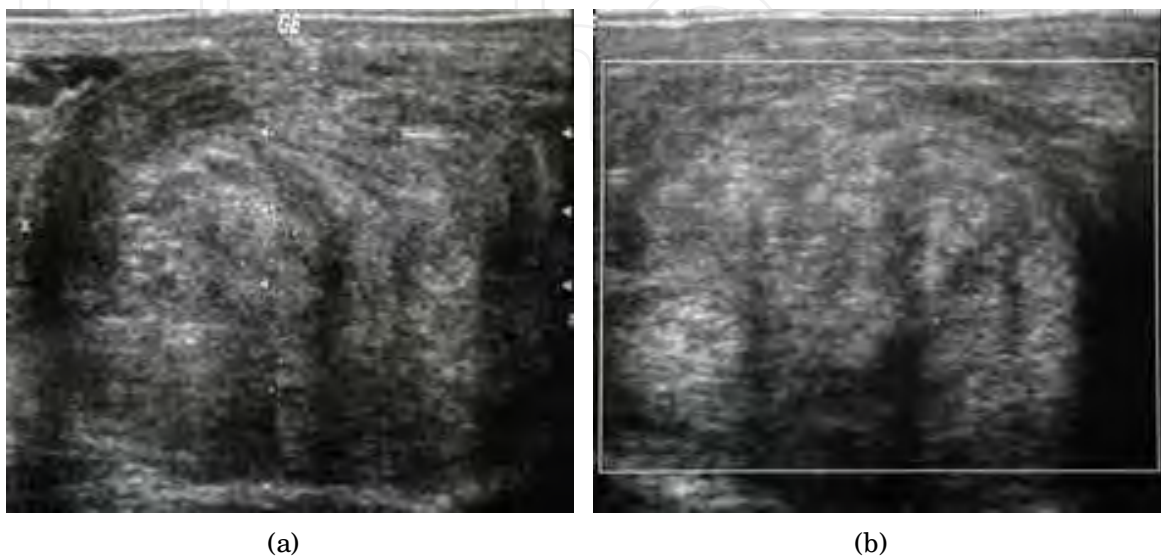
Leiomyoma arising from tunica albuginea (Reproduced with permission from John Wiley and Sons publishing company License number 2643411100095, *Journal of Clinical Ultrasound* 2004; 32:309–311). (a) Montage of 2 contiguous sonograms of a 67 year-old man shows a well-defined extratesticular mass with a whorl-shaped echotexture. (b) Color Doppler sonogram shows no internal vascularity. Note the presence of multiple shadows not associated with echogenic foci in the mass
